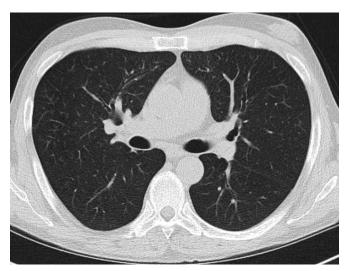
Follow-up axial chest computed tomography showing resolution of patchy interstitial alveolar airspace disease and pleural effusions relative to the previous examination.
